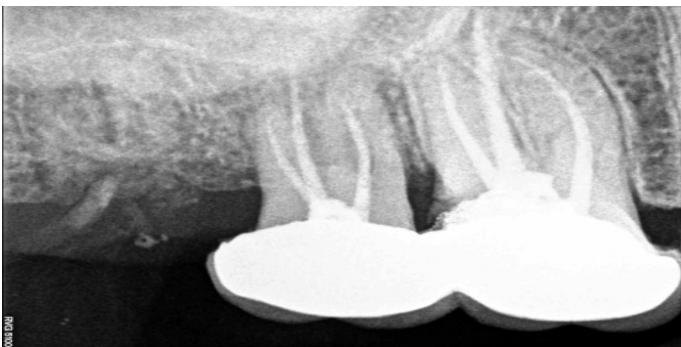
1 year follow up radiograph
